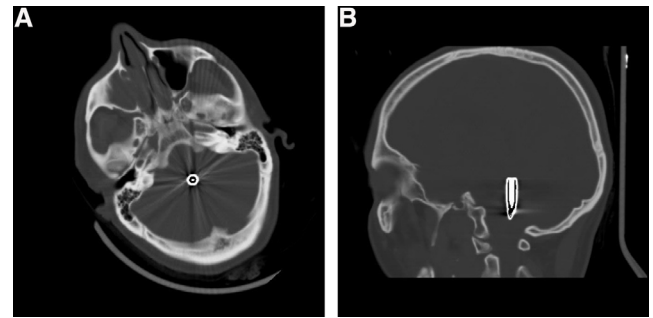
(a and b) Axial and sagittal CT image showing penetrating injury due to a gunshot wound in a 26-year-old man.
